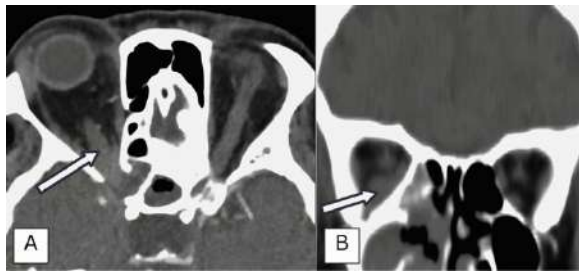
Brain CT Scan with gadolinium contrast done Day 5 of admission showing ill-defined enhancing mass centered in the right mucosal pharyngeal space, with mass effect, 6.7 x 3.9 x 5.2 cm (AP x T x CC), including the right orbital apex with resultant compression of the right optic nerve at axial view (A), and hyperdensities around the right medial rectus and inferior rectus at coronal view (B).
